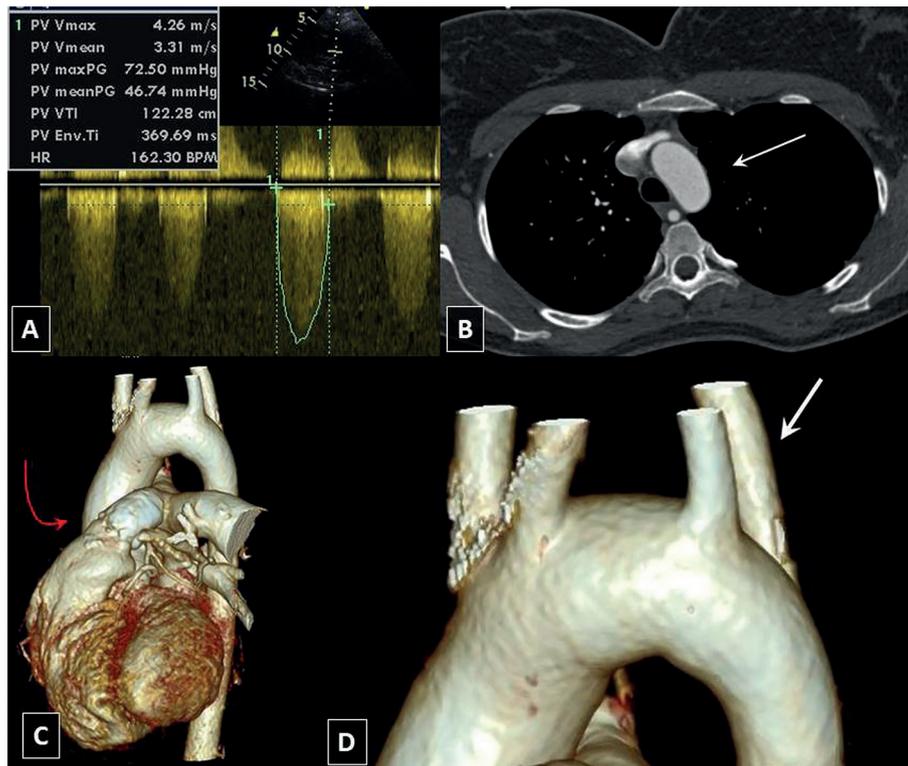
Patient 1 A) Transthoracic echocardiography, parasternal short axis view. Significant pressure gradient across the pulmonary homograft; B) Cardiac computed tomography, axial plane. White arrow indicates left-sided aortic arch; C) Cardiac computed tomography. Visible calcifications of the pulmonary homograft at the level of the pulmonary valve (red arrow); D) Magnification of panel “B” with a focus on the right aberrant subclavian artery (white arrow) branching-off from the left-sided aortic arch.
